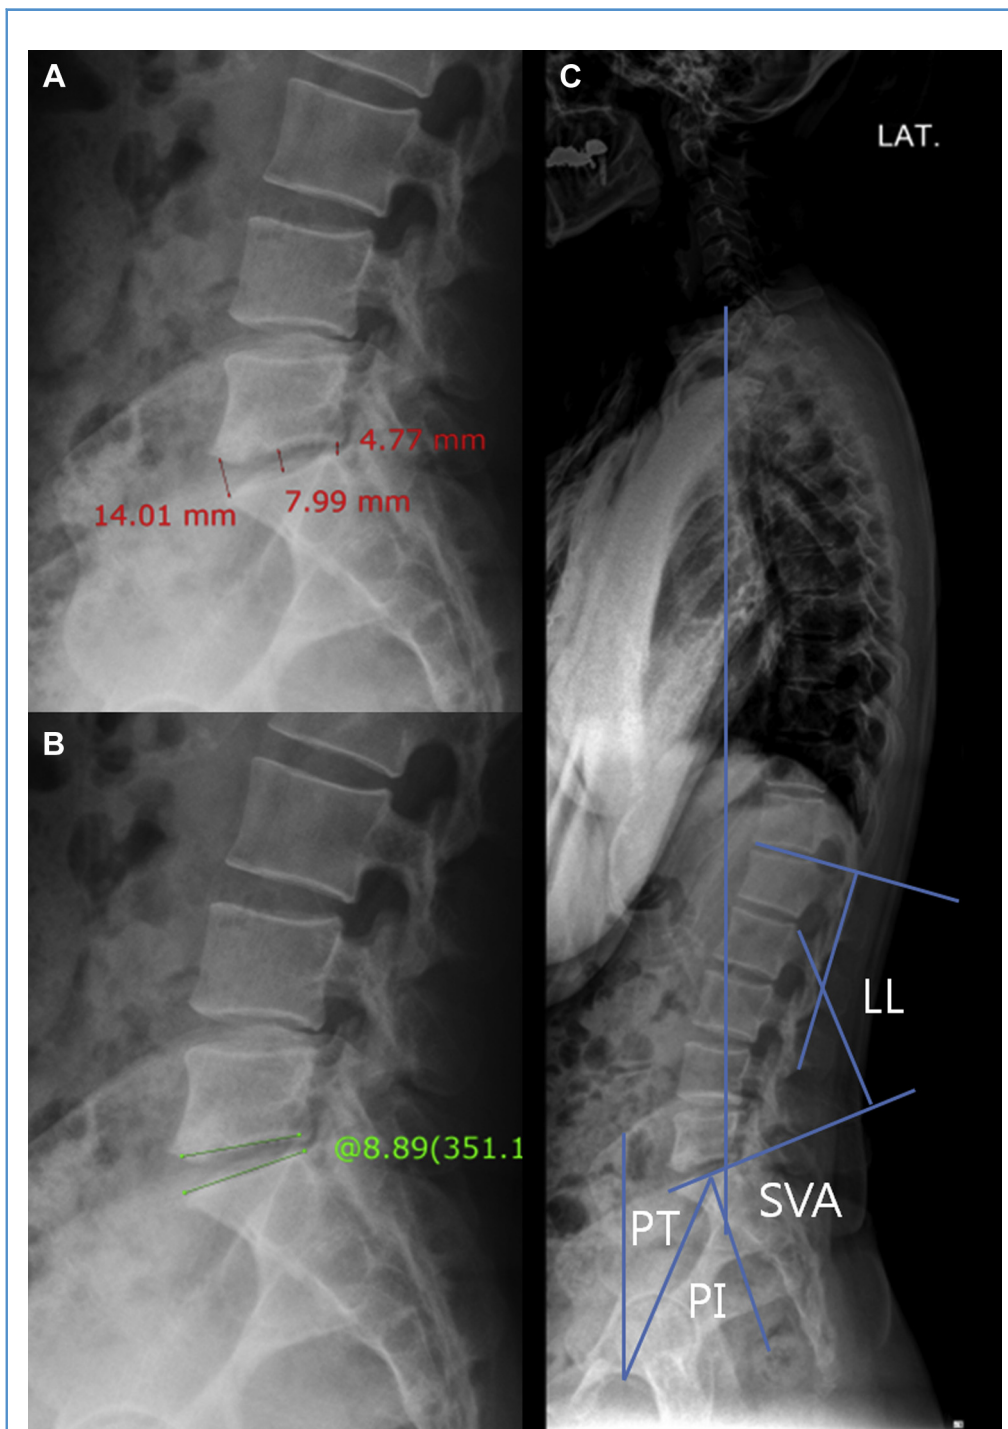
Spinal radiographic measurements. (A) Mean disc height was measured as the mean value of anterior, middle, and posterior disc height. (B) Segmental angle: sagittal Cobb angle between the lower end plate of the upper vertebra and the upper end plate of the lower vertebra. (C) C7-S1 sagittal vertical axis (SVA, plumb line from the center of the C7 vertebral body to the posterior sacral prominence on the lateral radiograph), lumbar lordosis (LL, sagittal
